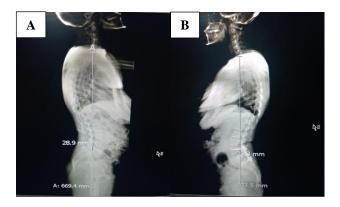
A) Pre and B) postoperative radiographic measurement sagittal vertical axis (SVA).
